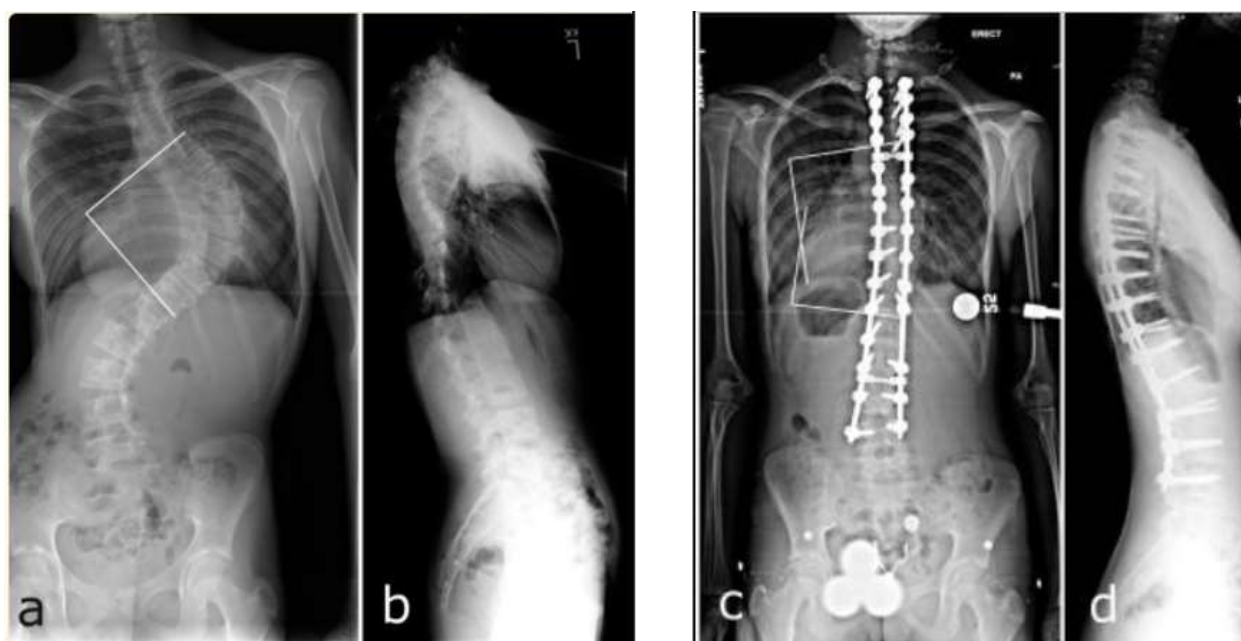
X-rays of the same patient pre and post operation (55)
